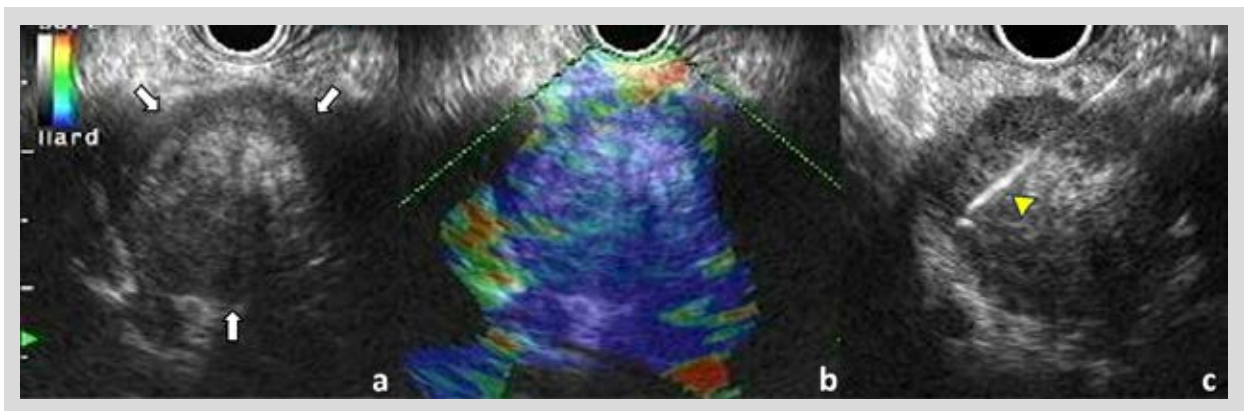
Linear-array endosonography. a) A hypoechoic heterogeneous mass with ill-defined borders at the pancreatic head (with the arrows). b) EUS elastography of the pancreatic lesion demonstrating the solid nature of the mass (blue color area). c) EUS-guided core-needle biopsy (yellow arrowhead).
